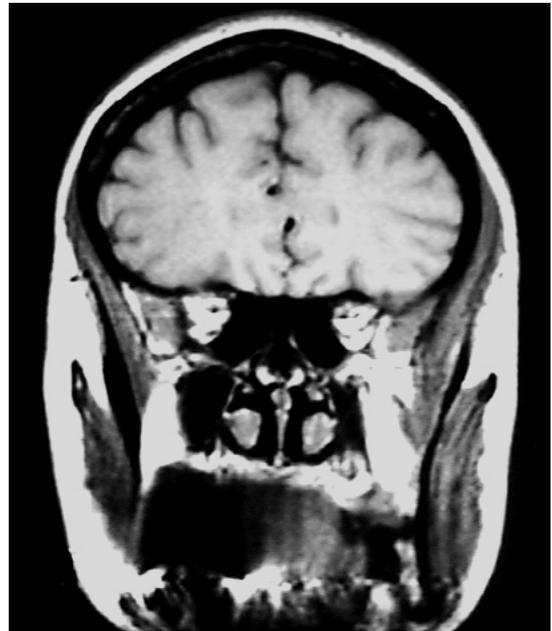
MRI scan through the genu of the corpus callosum. The frontal lobes are connected by the forceps minor, an extension of the genu of the corpus callosum
